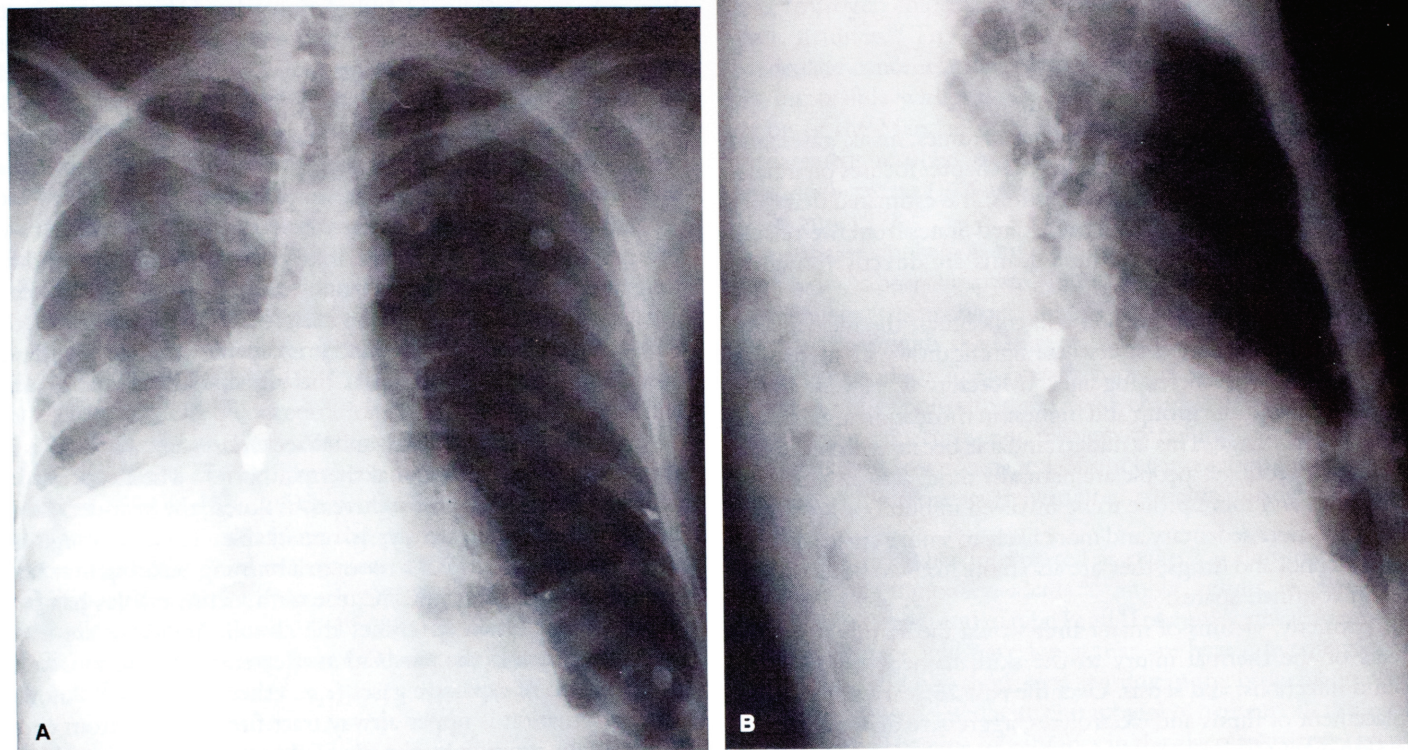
A bullet lodged in the right lower lobe bronchus produced obstructing pneumonia in a middle-aged man who was shot in the chest several years before. The bullet was extracted by bronchoscopy, and the pneumonic process resolved uneventfully. (A) Anteroposterior and (B) lateral chest x-ray films show the bullet and the resulting pneumonic process.
